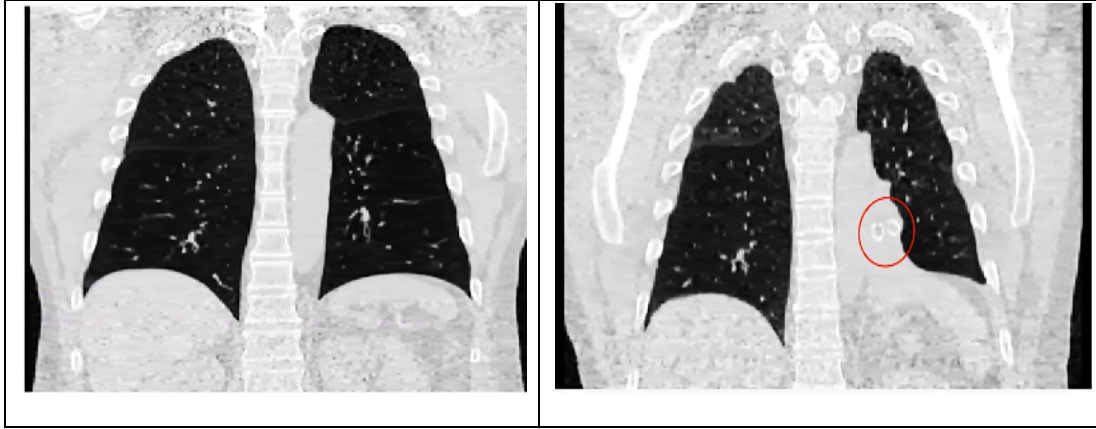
(a, c) Pre-BLVR and (b, d) post-BLVR CT images for two with identified endobronchial valves circled in red
